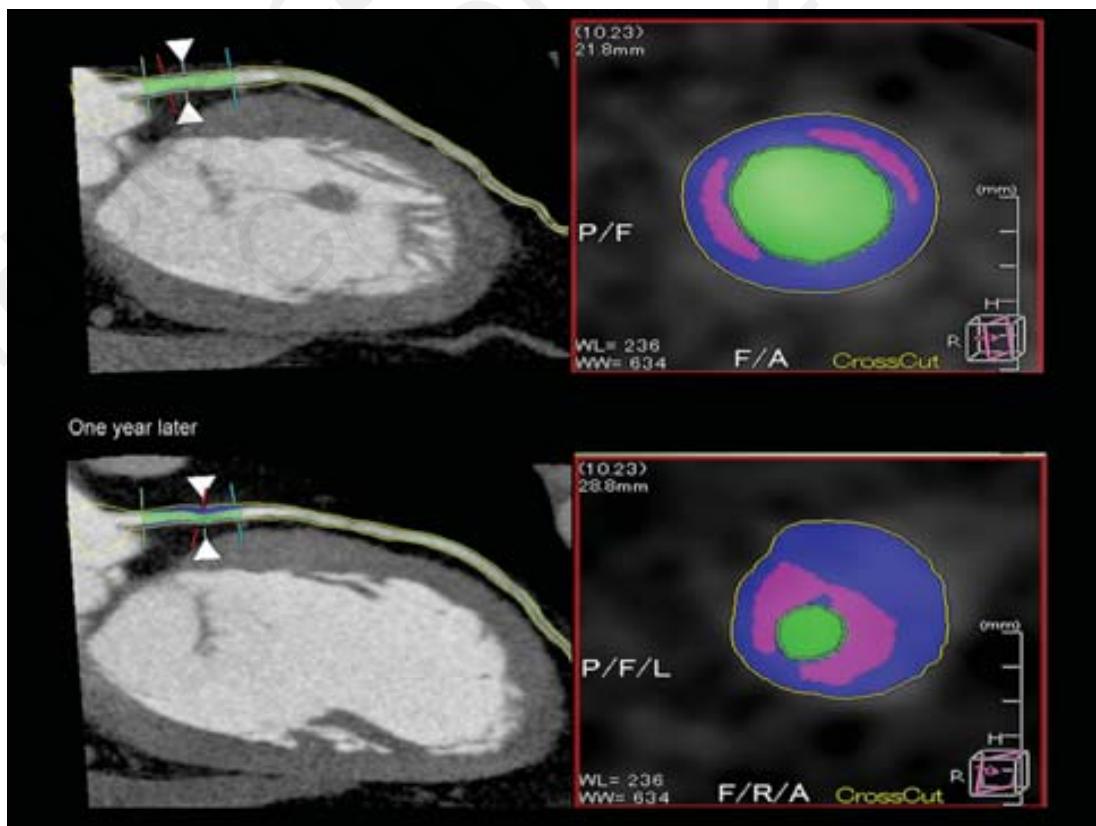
Serial computed tomography angiography performed at 1-year interval, demonstrates progression of low-attenuation plaques. Patient developed acute coronary event a few weeks after the second scan.
